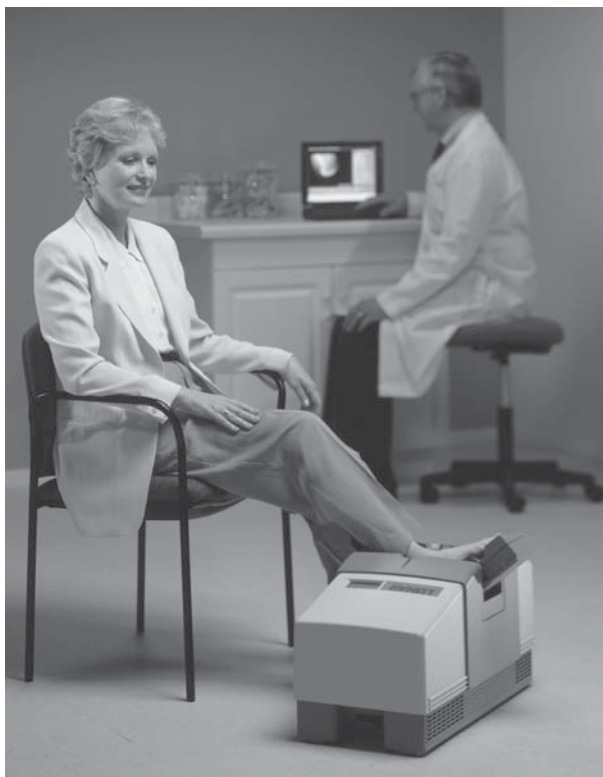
The Lunar PIXI®. A peripheral dual energy X-ray absorptiometer shown here in the configuration used to measure bone density in the calcaneus. The device can be reconfigured and used to measure bone density in the forearm. Photograph courtesy of GE Medical Systems, Madison, WI.
